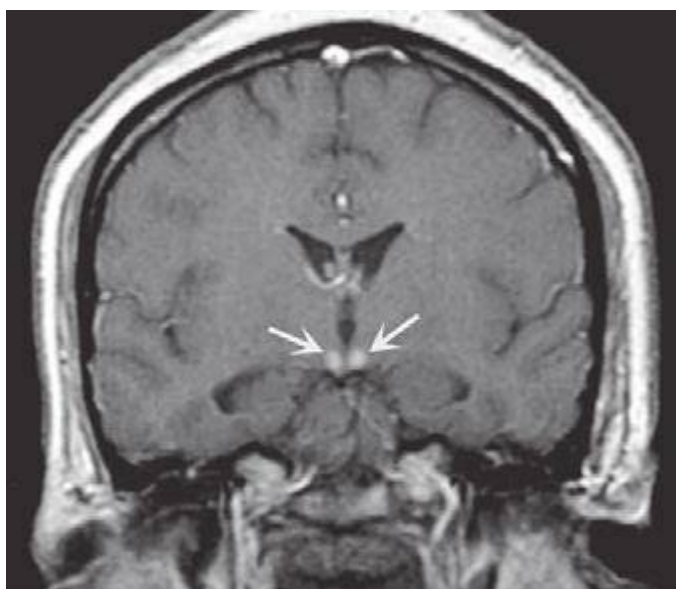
Wernicke's disease. Coronal T1-weighted postcontrast magnetic resonance imaging reveals abnormal enhancement of the mammillary bodies (arrows), typical of acute Wernicke's encephalopathy.
